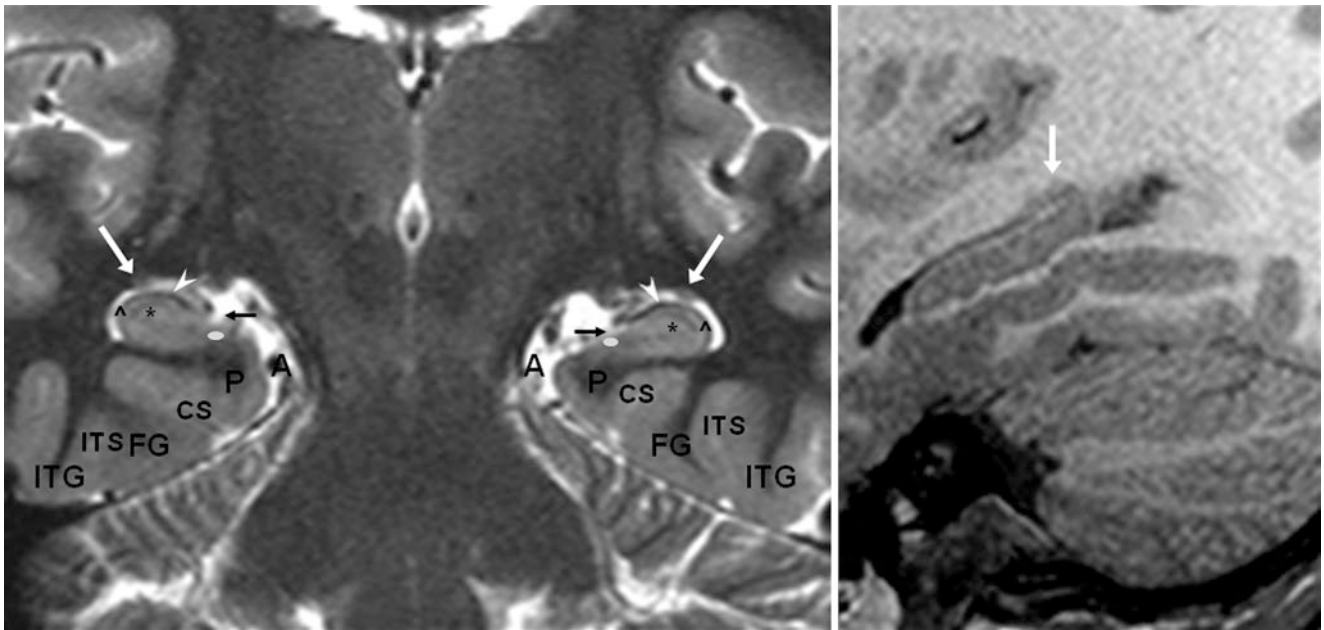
A 10 year old with neurocognitive decline had a negative MRI. On a coronal T2WI through the hippocampus (*left*), the caudate tail (*arrows*) is seen on the left better than on the right; this is consistent with a sagittal T1WI (*right*). Note the white matter of the alveus (*arrowheads*), hippocampal sulci (*tiny arrows*), CA2 of the cornu ammonis
